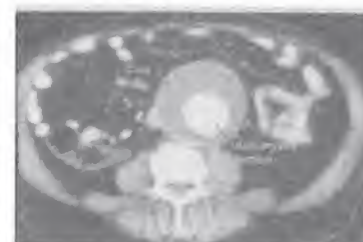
CT scan showing AAA with a thrombus inside.
